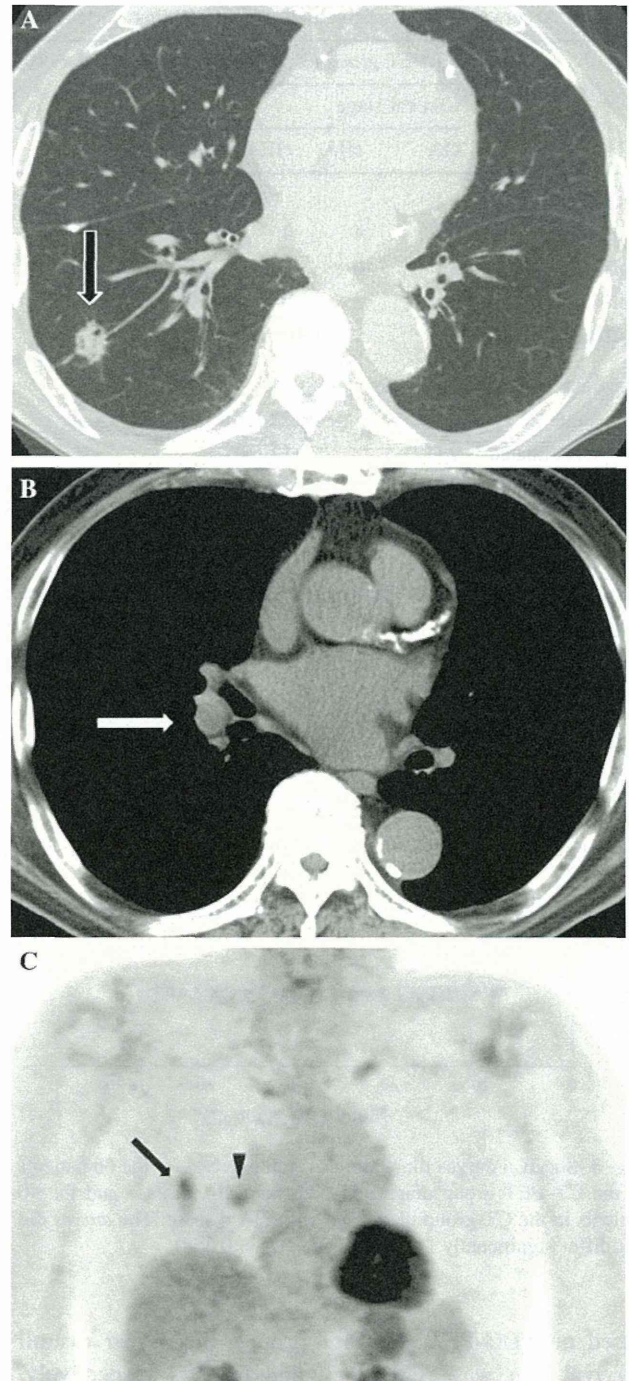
A 50-year-old woman with large cell carcinoma, pT1aN2M0, stage IIIA Axial CT image shows 1.2-cm solid nodule (*arrow*) in right upper lobe (a). Prevascular lymph node (#3a) is not enlarged (b). FDG-PET image shows hypermetabolism at right upper lobe nodule (*arrow*) (SUVmax = 15.7) and #3a lymph node (*arrowhead*) (SUVmax = 5.4) (c). Right upper lobe nodule was confirmed to be large cell carcinoma and mediastinal lymph node to be metastasis
